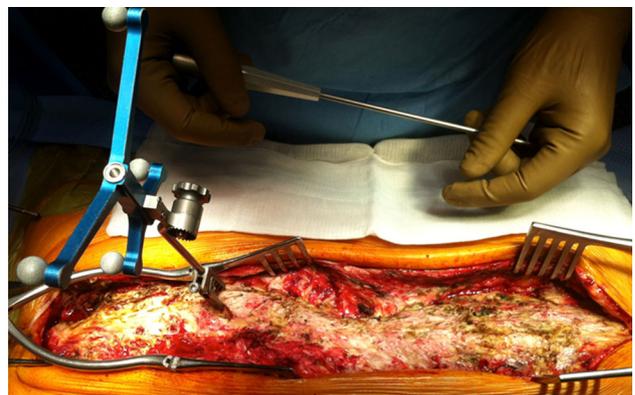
Preoperative CT-scan and navigation can be particularly useful to identify the local anatomy to place the instrumentation and to guide the osteotomy
